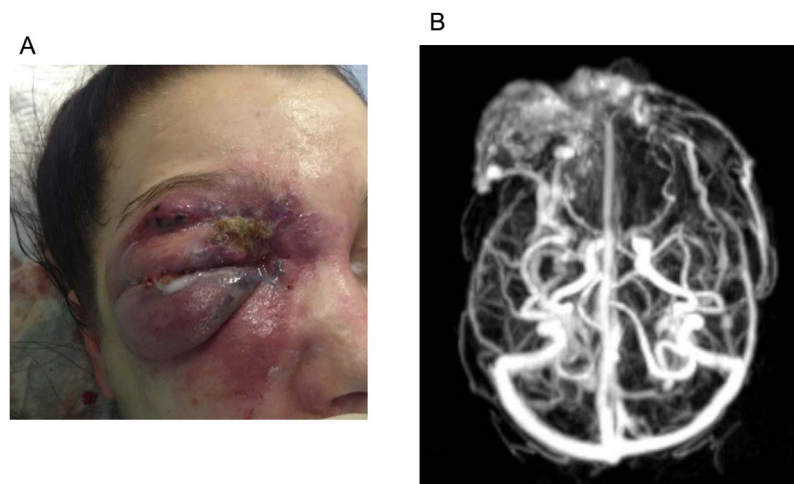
AVM of the right eye. Pre- and retro-orbital arterio-venous fast-flow shunts with clinically apparent swelling, pulsation, hyperthermia of the skin, ulceration and bleeding. The patient complained of almost total loss of vision on the right eye (A). MRI confirms the massive arterio-venous shunts on axial post contrast angiography (B).
